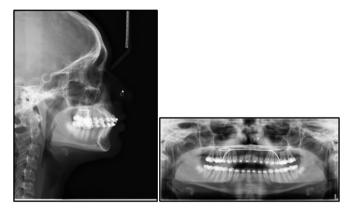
MID TREATMENT RADIOGRAPHS
